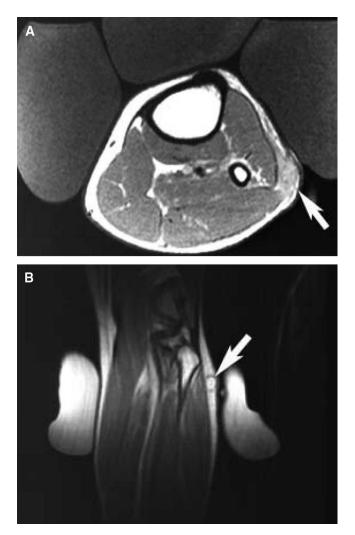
A, axial magnetic resonance imaging (MRI) of the left leg of the patient showing a botfly larva (white arrow). B, coronal MRI showing the botfly larva (white arrow).
